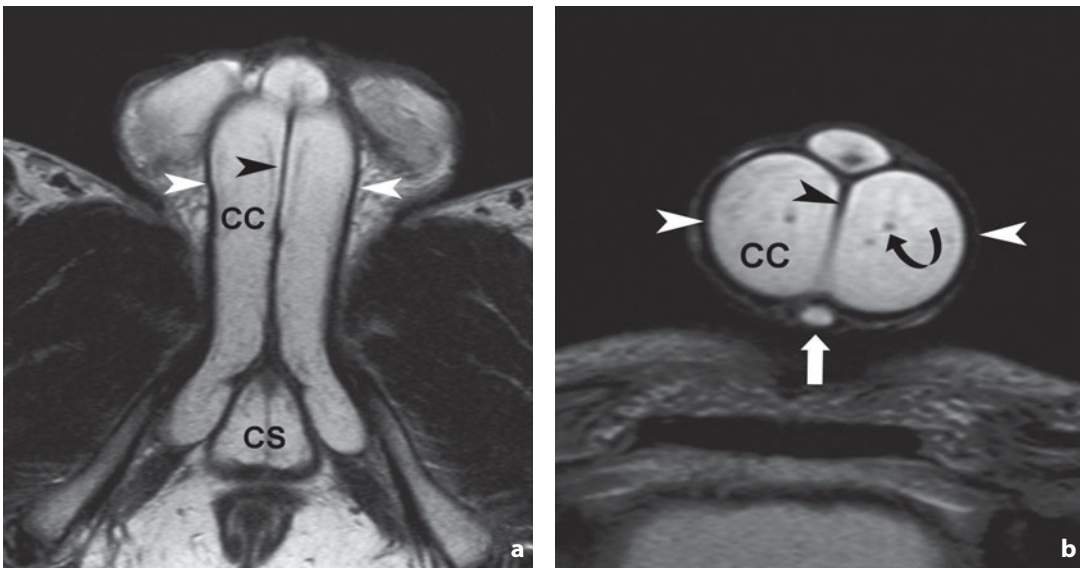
Magnetic resonance. Penis. Axial T2-weighted scans, acquired after pharmacologic stimulation at the level of the root (a) and the shaft (b). The *arrowheads* indicate the tunica albuginea and the intercavernosal septum, the *arrow* indicates the dorsal vein, and the *curved arrow* indicates the cavernosal artery. CC, corpora cavernosa, CS, corpus spongiosum
